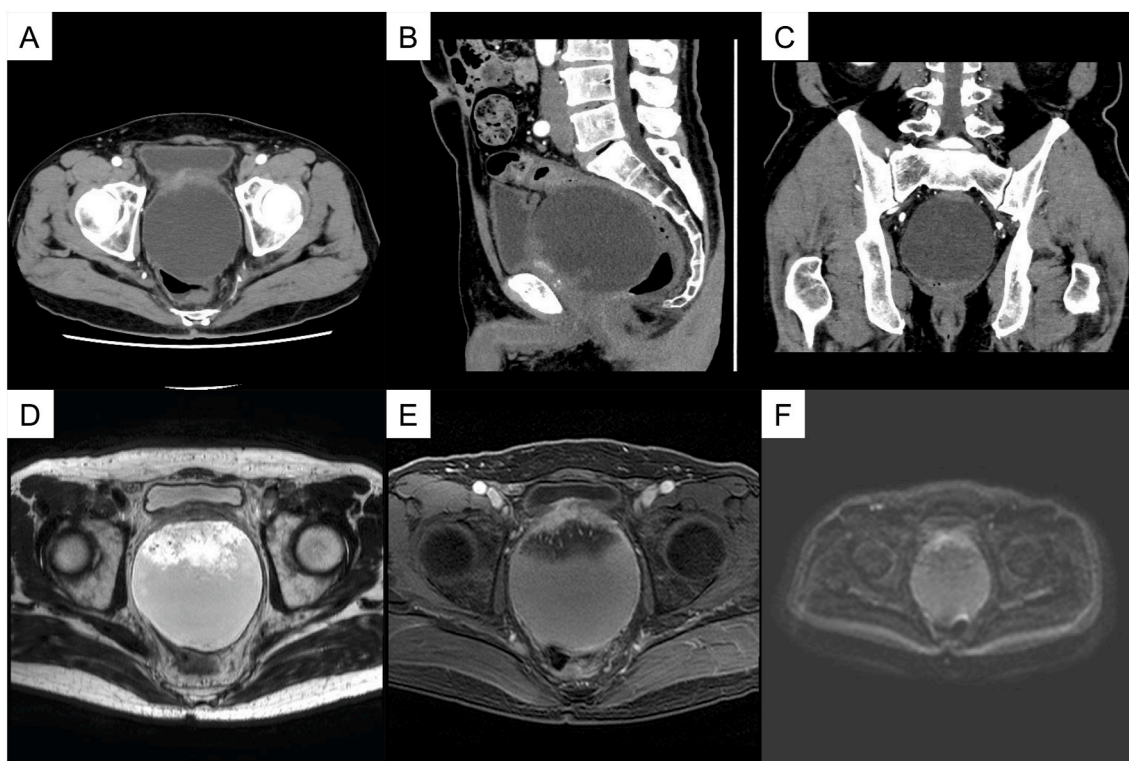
Contrast enhanced computed tomography (CT) and magnetic resonance imaging (MRI) of the prostate. (A) axial (B) Sagittal (C) Coronal CT. The entire pelvic area is occupied by the cyst, and the rectum was compressed. (D) T2 weighted (E) Contrast enhanced T1 weighted (F) Diffusion-weighted. A mass volume of 85*83*90 mm was found in the pelvis. The dorsal side shows high signal on T2 weighted and T1 weighted.
